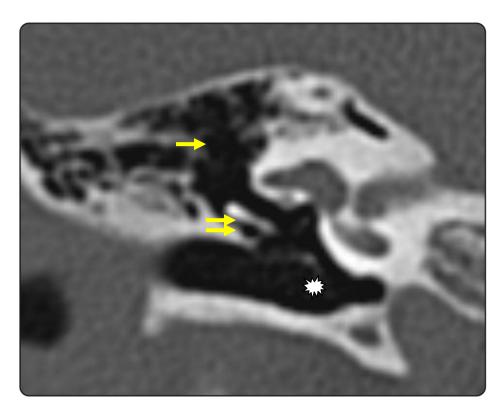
Coronal HRCT image showing normal epitympanum(arrow), mesotympanum (double arrows) and hypotympanum(asterix).
